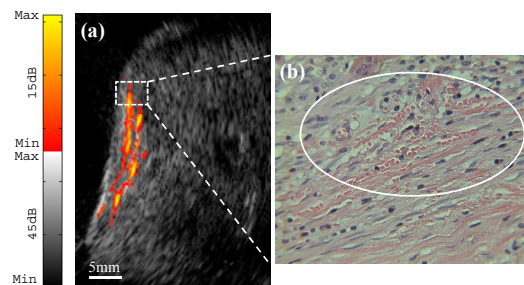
(a) *Ex vivo* co-registered photoacoustic/ultrasound image of postmenopausal ovary with malignancy. (b) Reveals a cluster of microvessels ($\times 40$) from the rectangular region indicated in (a).
